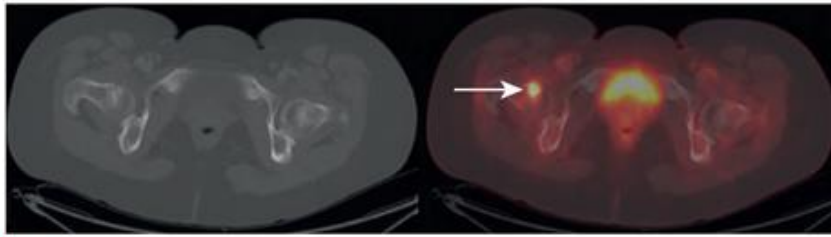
Axial CT and fused FDG PET/CT that correspond with Fig. 1.3. The FDG focus in the right pelvis localizes to the right femur (*arrow*) and is suspicious for an osseous metastasis. Biopsy proved this was an osseous metastasis.
